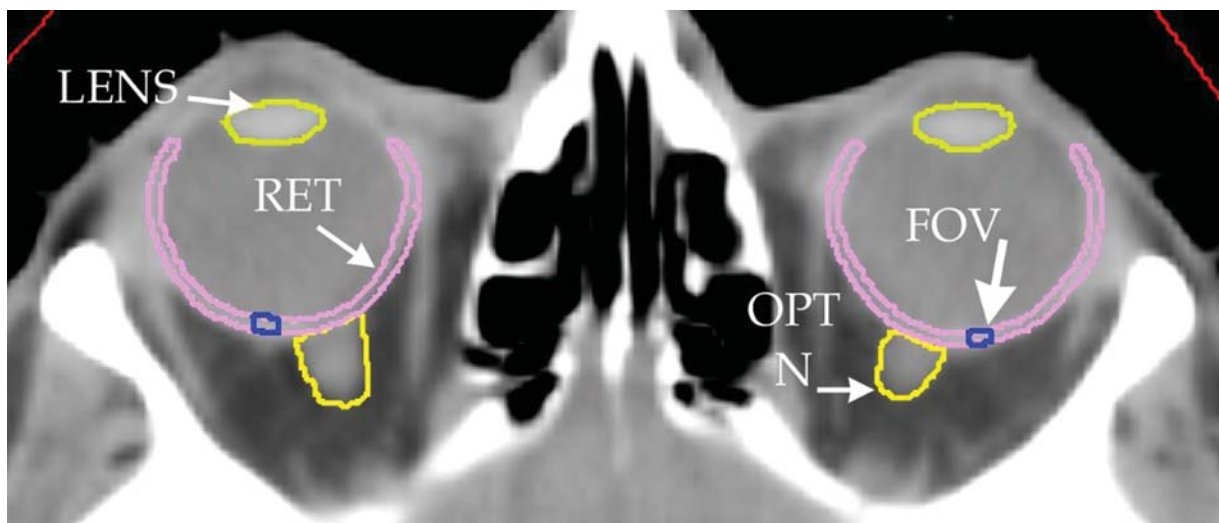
Axial slice from a planning CT. The lens is shown as well as the retina (RET) and its fovea (FOV). The retina contour, more easily seen in the CT than in the MR scan, includes the retina, the choroid, and the sclera. The fovea is indicated just lateral to the optic disk, the region where the optic nerve (OPT N) exits the globe. (Figure is provided courtesy of Dr. Barbara Fullerton.)
